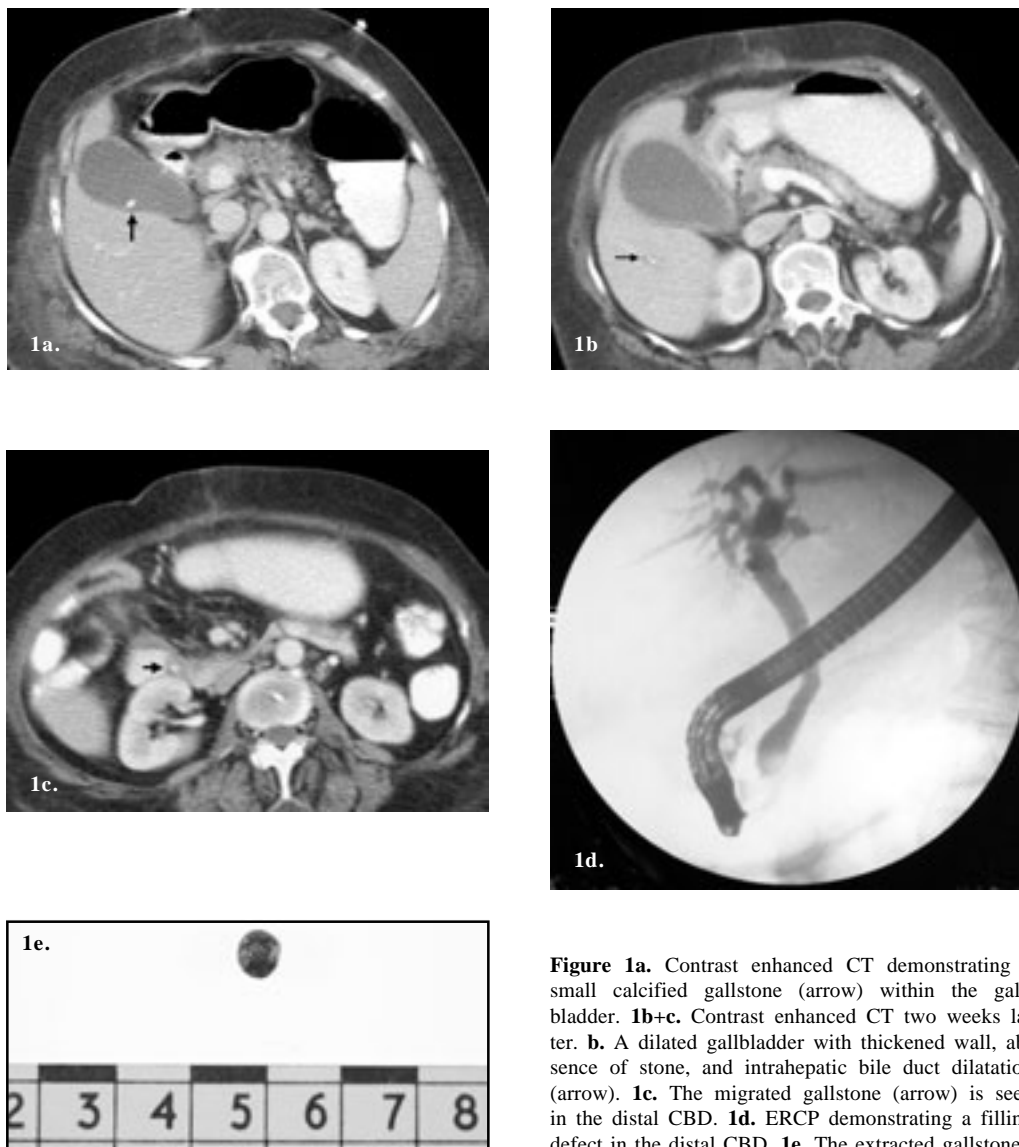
Contrast enhanced CT demonstrating a small calcified gallstone (arrow) within the gallbladder. 1b+c. Contrast enhanced CT two weeks later. b. A dilated gallbladder with thickened wall, absence of stone, and intrahepatic bile duct dilatation (arrow). 1c. The migrated gallstone (arrow) is seen in the distal CBD. 1d. ERCP demonstrating a filling defect in the distal CBD. 1e. The extracted gallstone.
